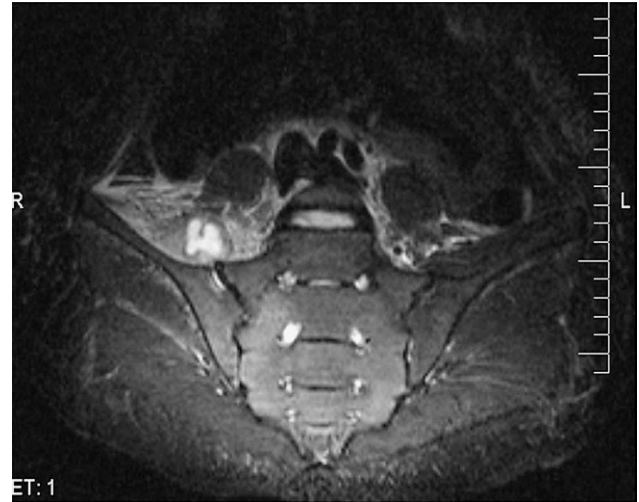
Sagittal section of pelvic MRI in T2 STIR sequence, 5 days after admission, with increase of the right sacroiliac joint space and adjacent fluid collection in the width of the psoas muscle.
